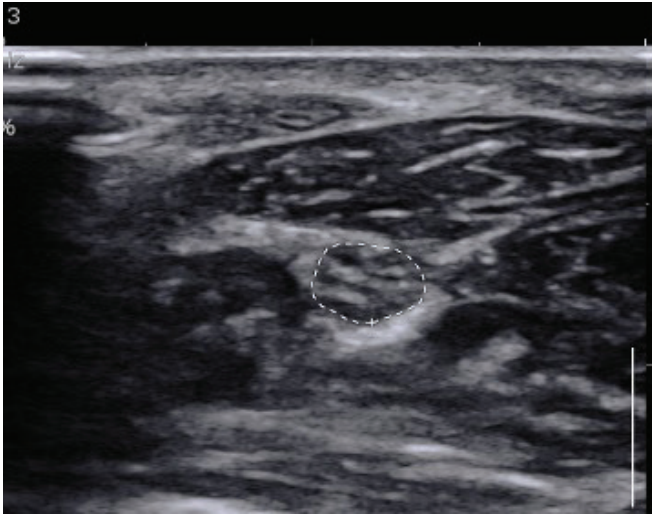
Normal sonographic appearance of peripheral nerve-honeycomb appearance marked with dotted lines).
